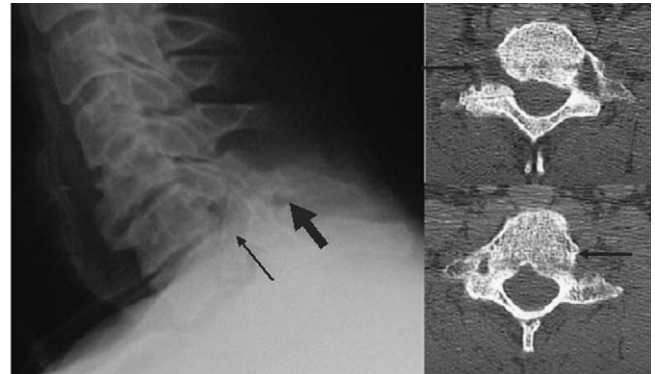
Repeated lateral radiograph and high-resolution computed tomography, showing union through the spondylolysis and anterior part of the injury (thin arrows) and also spinous process disruption (thick arrow).
